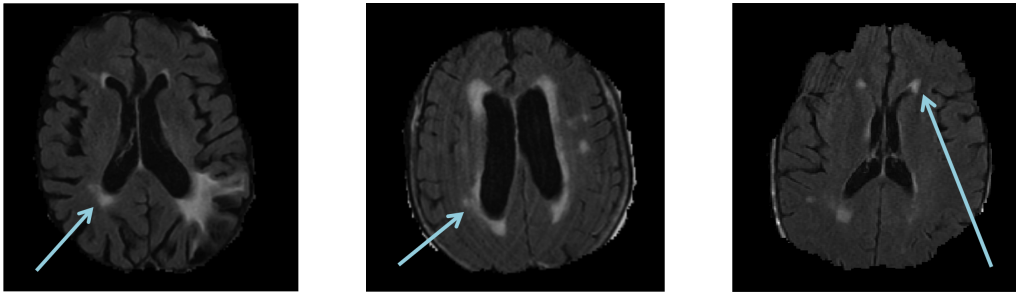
Sample two-dimensional axial slices of T2-FLAIR brain MRI showing white matter hyperintensity (highlighted by blue arrows) in varying degrees.
